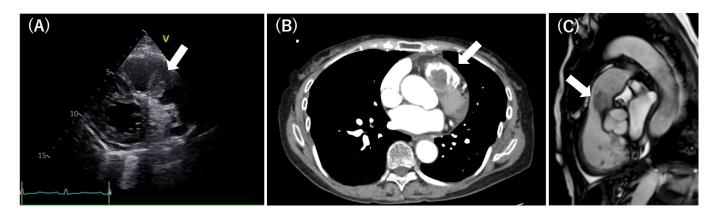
A) Transthoracic echocardiography examination reveals a mobile mass protruding into the pulmonary artery (white arrow); B) Computed tomography shows the filling defect in the right ventricular outflow tract (white arrow); C) Magnetic resonance imaging shows a mobile mass attached to the infundibulum beneath the pulmonary valve (white arrow).
